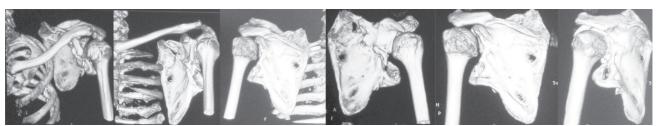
CT of shoulder 18 months after trauma.
